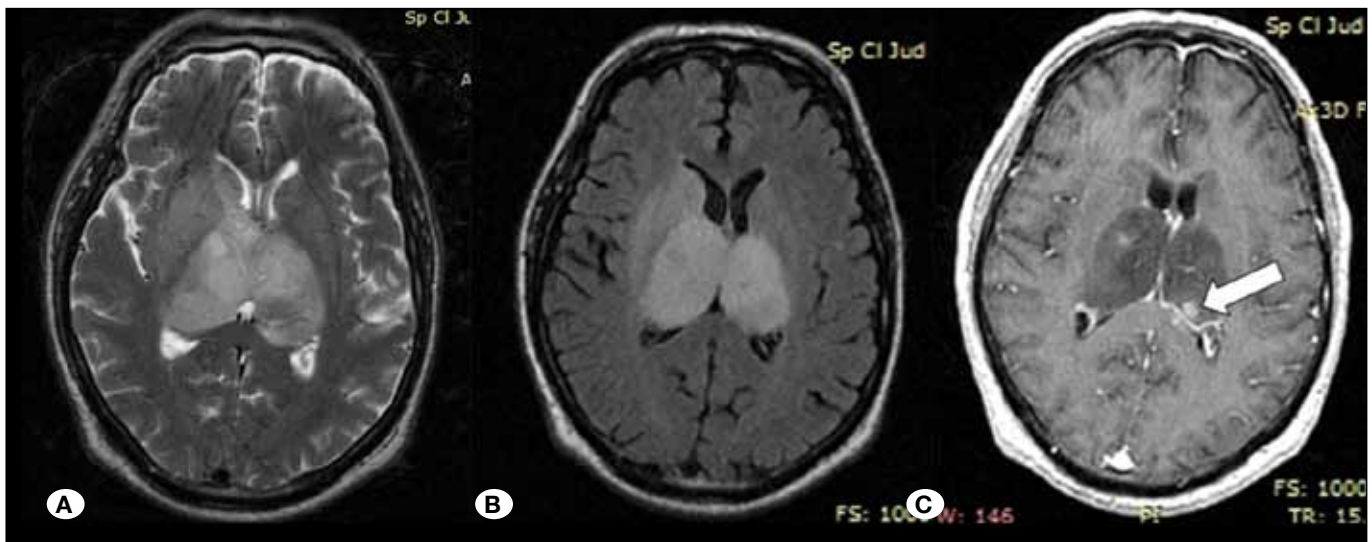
MRI imaging. A) Axial T2-weighted MR shows hyperintensity and bilateral symmetrical diffuse enlargement of thalami. B) Axial FLAIR sequence shows bilateral hyperintensity. C) T1-weighted gadolinium-enhanced image with the arrow showing the minimal focal uptake in the left thalamus.
